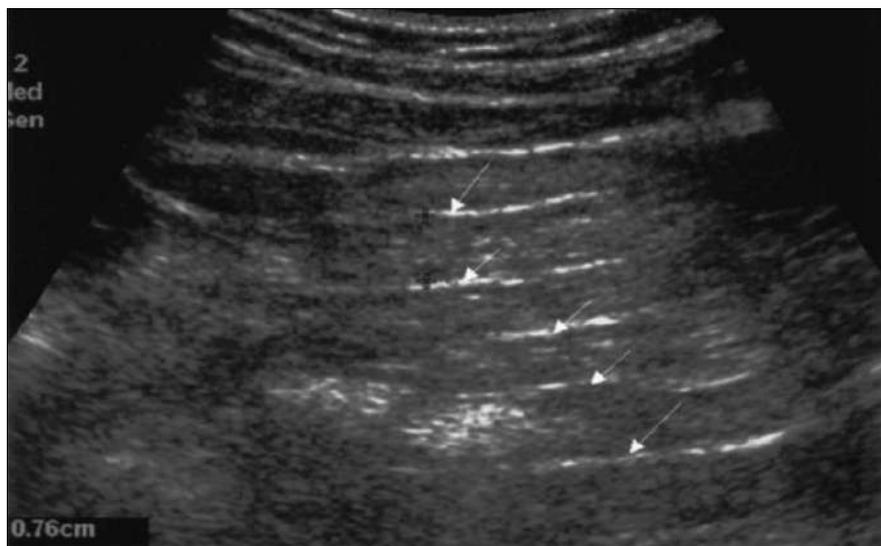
Ultrasonogram of mesenteric leaves. Each mesenteric leaf is indicated by highly reflecting peritoneal surfaces (arrows). The maximum mesenteric thickness on the image was measured with the callipers (+).
